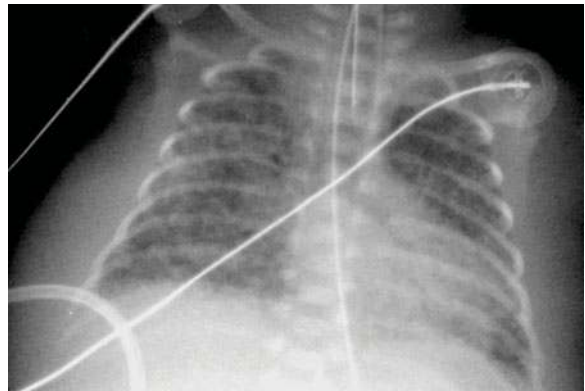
Chest radiograph (day 12) of a premature infant born at 25 weeks gestation. There is coarse bilateral pulmonary opacification in keeping with pulmonary infection. Multiple sterile abscesses were found at post-mortem examination 2 days later
